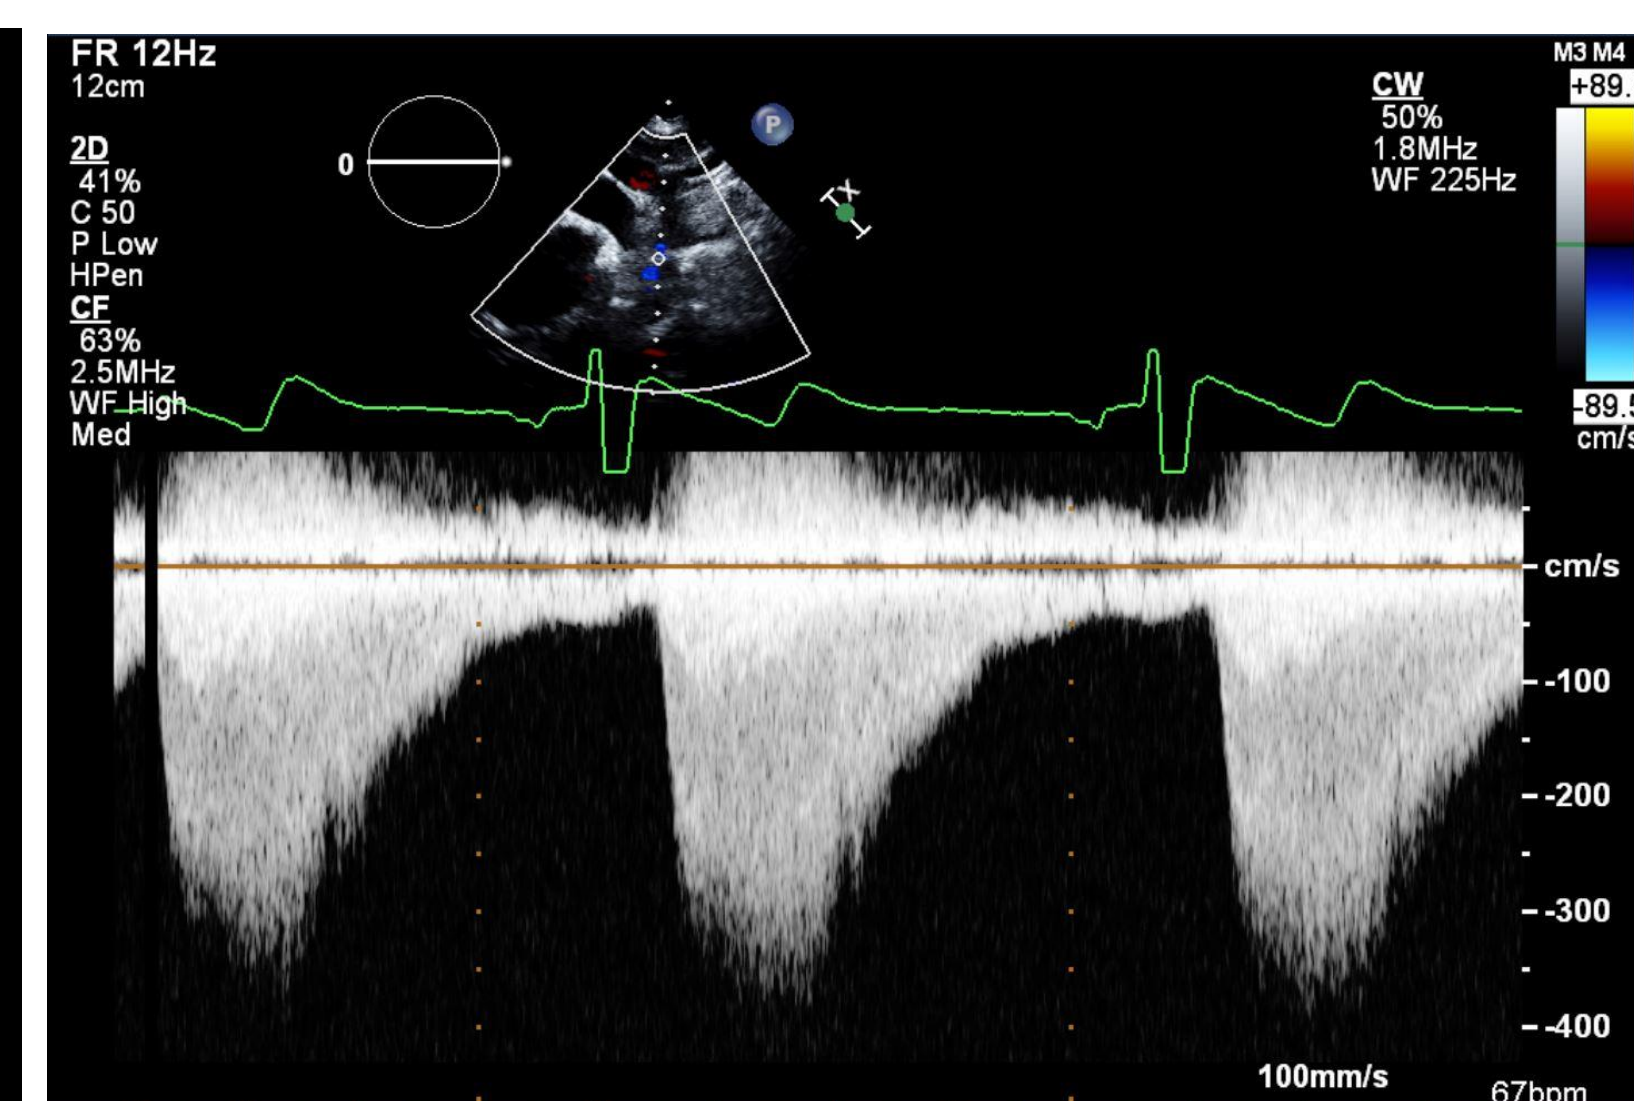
Echocardiogram with Doppler consistent with CoA.
